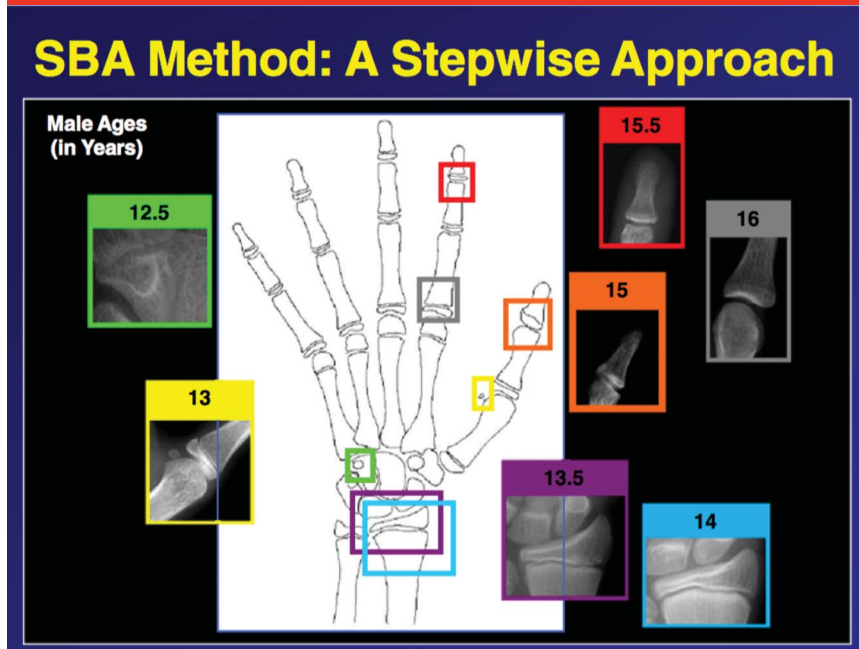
Figure showing shorthand bone age assessment for males. This figure demonstrates a characteristic change in the bone age radiograph at key time points during the male adolescent growth spurt. (Reproduced with permission from Heyworth BE, Osei DA, Fabricant PD, et al: The shorthand bone age assessment: A simpler alternative to current methods. *J Pediatr Orthop* 2013;33:569-574.)
